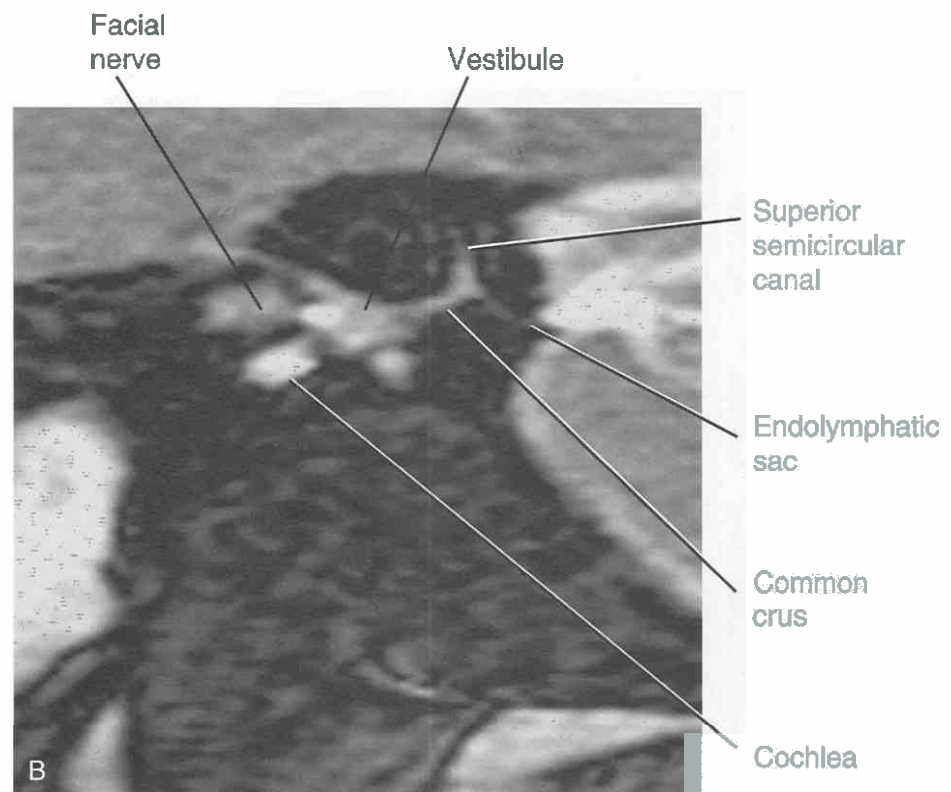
Sagittal views, normal anatomy. *A*, Sagittal CT reconstruction centered at the level of the middle ear. The oval and round windows are seen with their associated niches. The vestibule and the basal turn of the cochlea are seen as well. The superior and posterior semicircular canals are visible. The tympanic sinus is continuous with the round window. *B*, Sagittal MR section.
